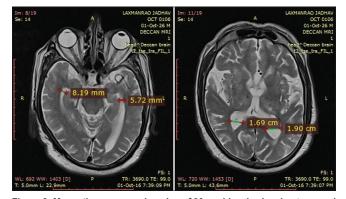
Magnetic resonance imaging of 90 yr old male showing temporal and occipital horn diameter
